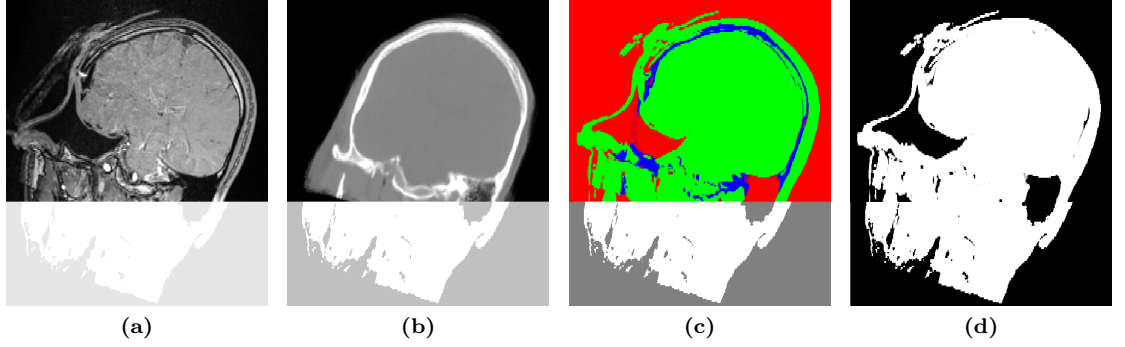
Air-tissue segmentation. (a) Intraoperative T1w+T2w sum image. The section runs through a plane close to the anatomical coronal plane with the head at an angle due to intraoperative orientation. (b) An accompanying pseudo-CT (range -1000–1000 HU). (c) The result of the proposed segmentation within the intraoperative FOV (red for air, green for soft-tissue, blue for bone). (d) The final air-tissue segmentation (black for air, white for tissue). The appended inferior volume outside of the intraoperative FOV is an approximate air-tissue segmentation based on preoperative T1w MRI.
